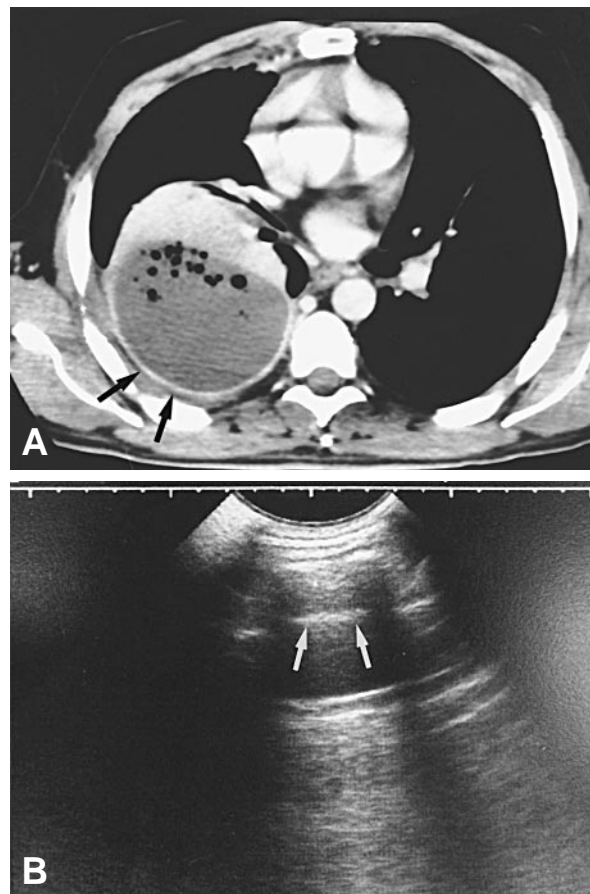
A, Axial contrast-enhanced CT of the chest at the floor of the left atrium shows gas inclusions, thickening, and increased contrast uptake of the parietal pleura (arrows) in a 42-year-old patient with stage II empyema. No loculations are detectable. B, Chest ultrasonography of the same patient as in A reveals loculations (arrow) and a thickened visceral pleura. These findings were subsequently confirmed at video thoracoscopy.
